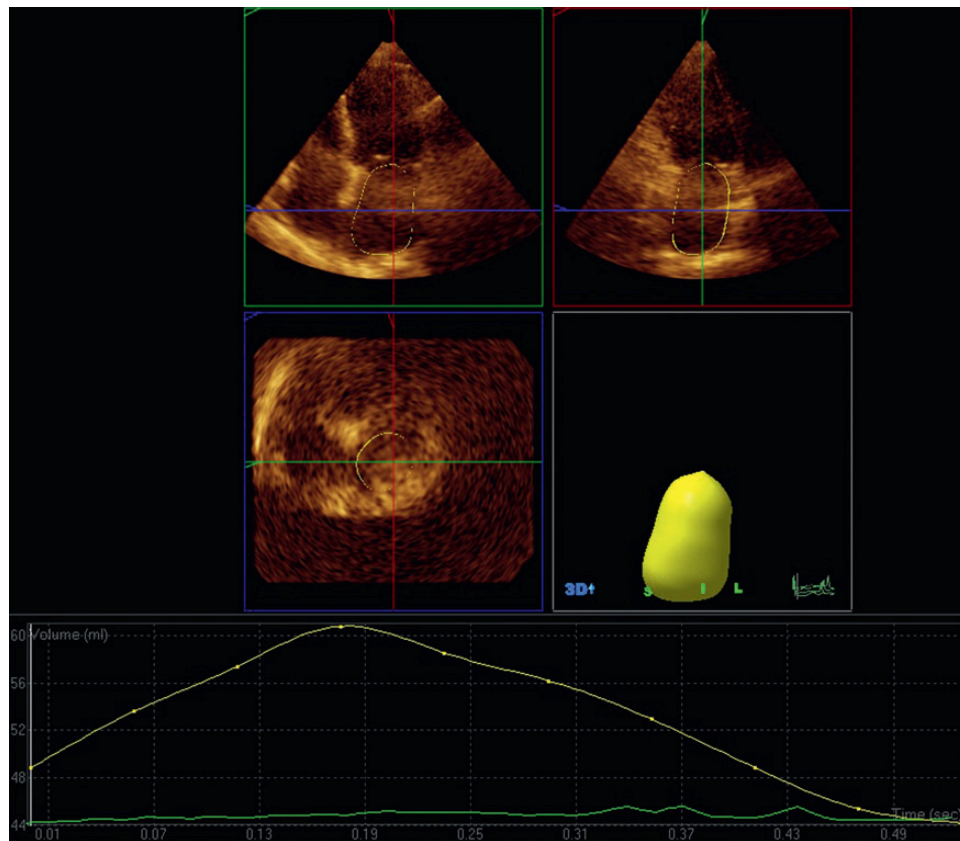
Assessment of left atrial volumes using RT3DE. Automatic border detection is obtained marking 5 reference points in the apical 2- and 4-chamber views (upper panel), and the left atrial 3-dimensional model is provided by the software. The changes in left atrial volumes during the heart cycle are plotted as a curve (lower panel).
